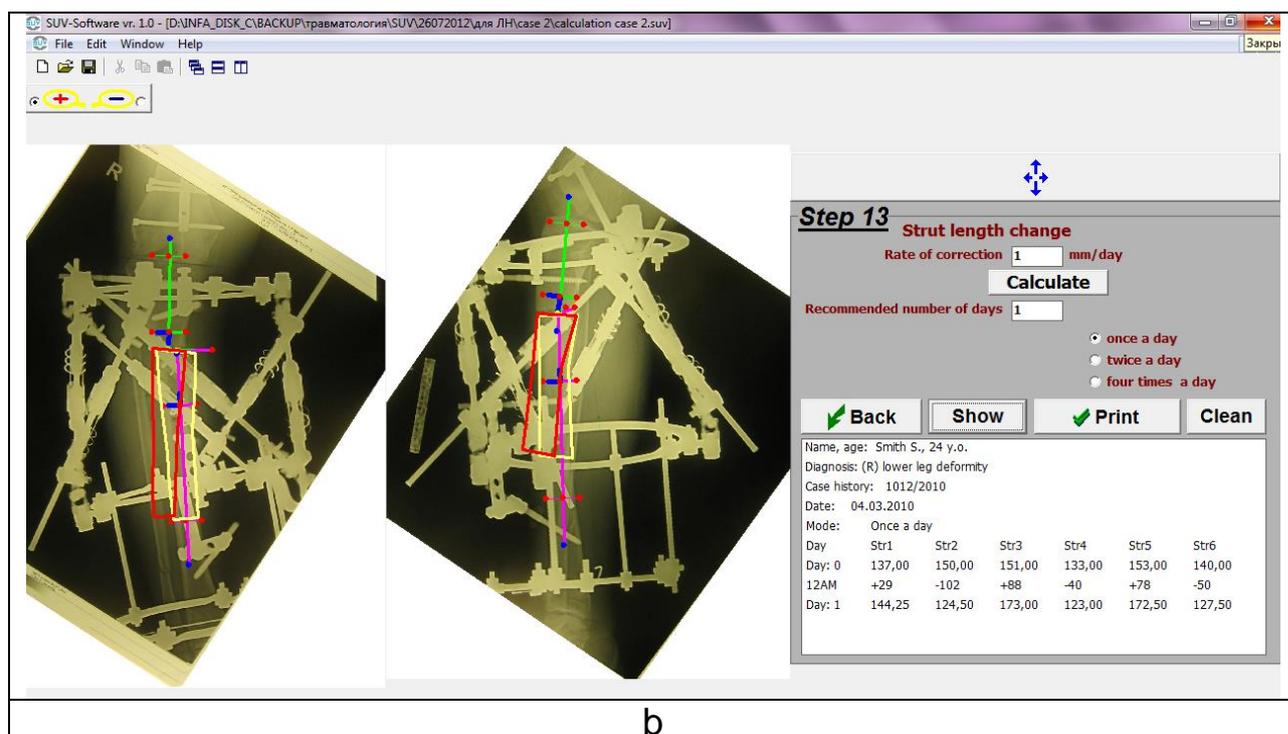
Ortho-SUV program window in Step 13 at acute deformity correction. a - number "1" is entered into window "Recommended number of days". b - there are three rows in table: initial strut length (row "Day: 0"), final strut length (row "Day: 1") and between them row "12AM" - number of clicks needed for change of strut length. First length of struts ## 1, 3 and 5 should be changed, because they are lengthened. Only after that it is necessary to shorten struts ## 2, 4 and 6.
